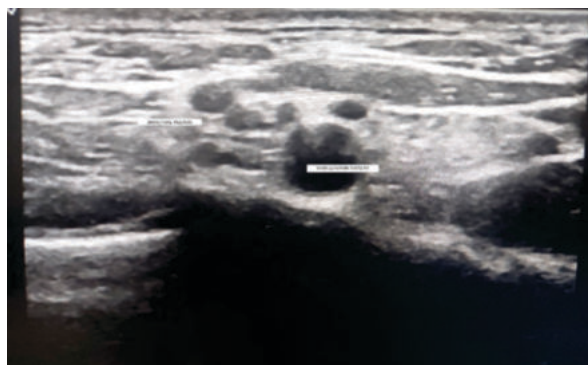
Ultrasonographic Anatomy Of The Brachial Plexus. The Upper, Middle And Lower Trunks Are Clearly Seen.
